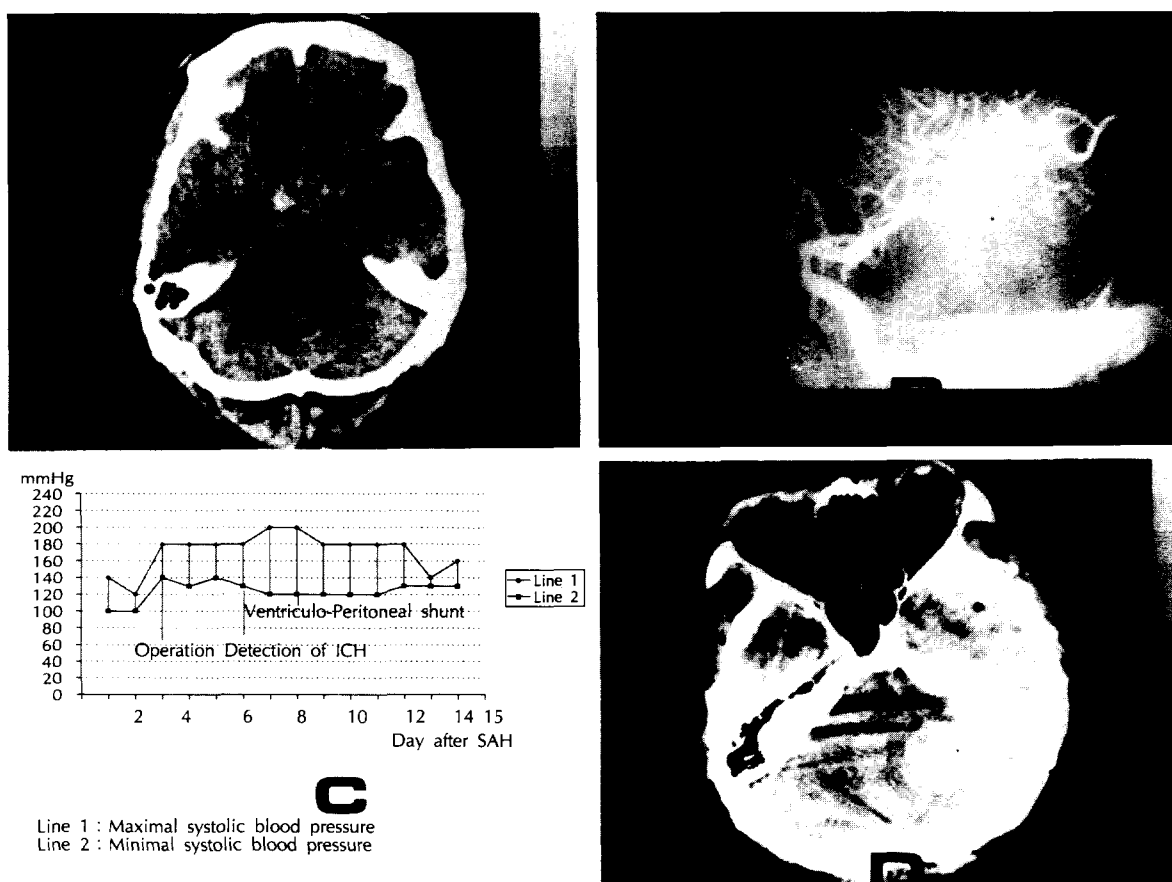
A) Brain CT shows thick SAH in all of the basal cisterns.
